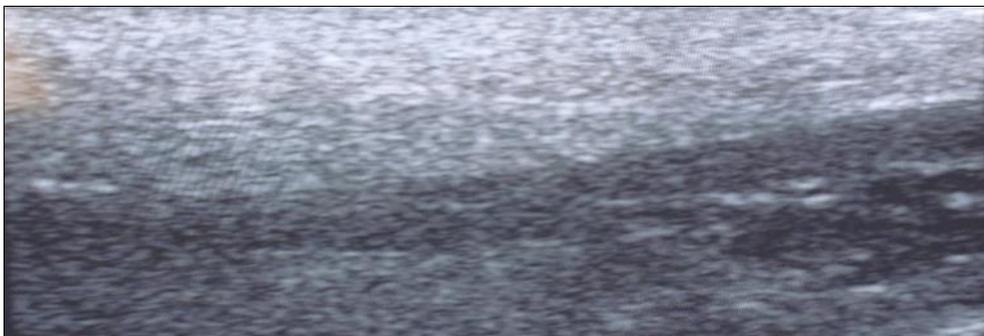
Normal parotid gland ultrasound
